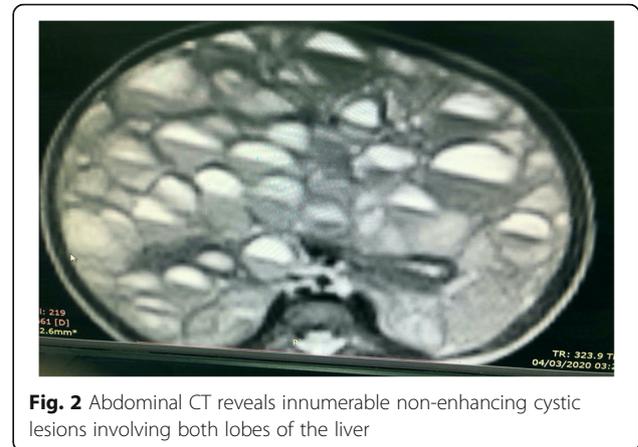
Abdominal CT reveals innumerable non-enhancing cystic lesions involving both lobes of the liver
